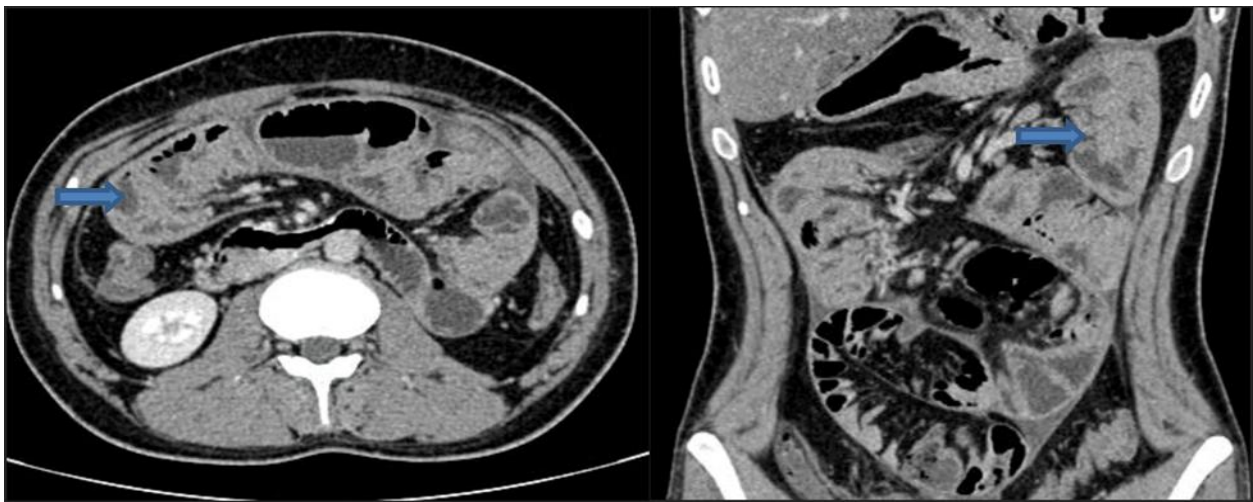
Axial & Coronal CT of case 1 shows clumping of bowel loops within a sac with few dilated bowel loops
